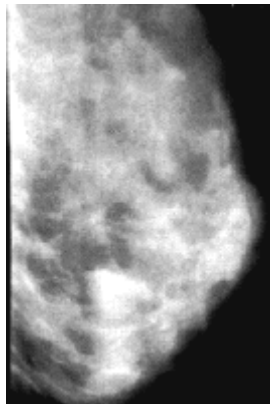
Mammogram of a dense breast. Comparison with Figure 2 suggests the much greater relative difficulty of spotting a tumor in dense breast tissue. (From *Mammography: Introduction*. (2003). Retrieved December 16, 2005, from Monash University Centre for X-ray Physics and Imaging Web site: <http://cxpi.spme.monash.edu.au/index.htm>)
